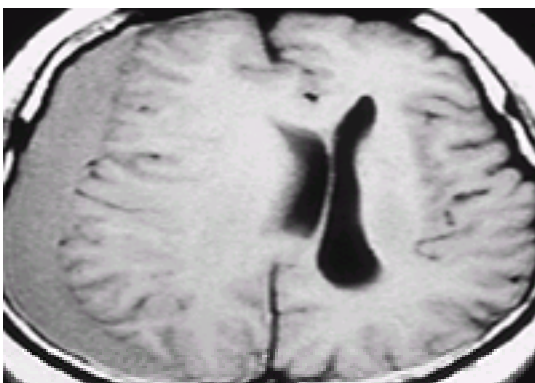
Subdural hematoma. This T₁-weighted magnetic resonance imaging image shows the classic appearance of a large acute subdural hematoma, with a crescent-shaped extra-axial hematoma that covers the entire right cerebral convexity. There is significant midline shift with compression of the right lateral ventricle and enlargement
